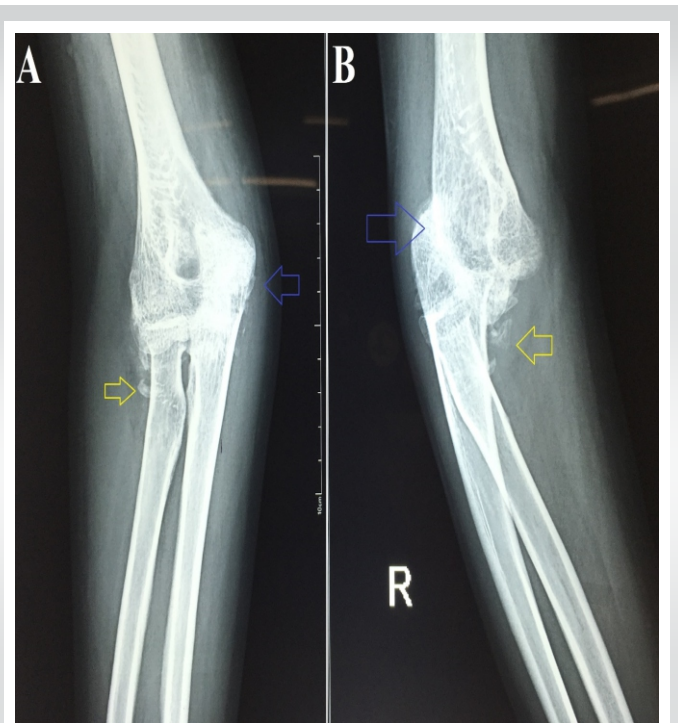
Radiographs of the wrist done when the patient presented to us. (a) Anteroposterior view and (b) lateral view showing ankylosis of the ulnohumeral joint (blue arrow) and heterotrophic bone formation around the elbow joint (yellow arrow).
